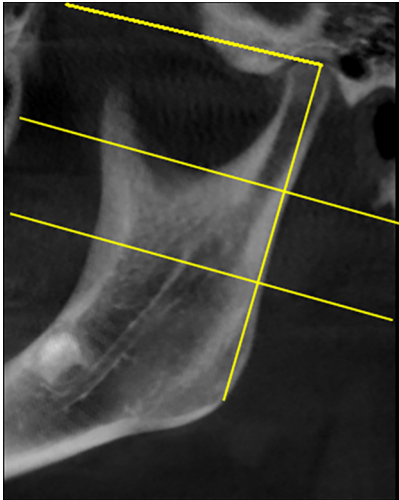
Cephalometric points on cone beam computed tomography (CBCT).
